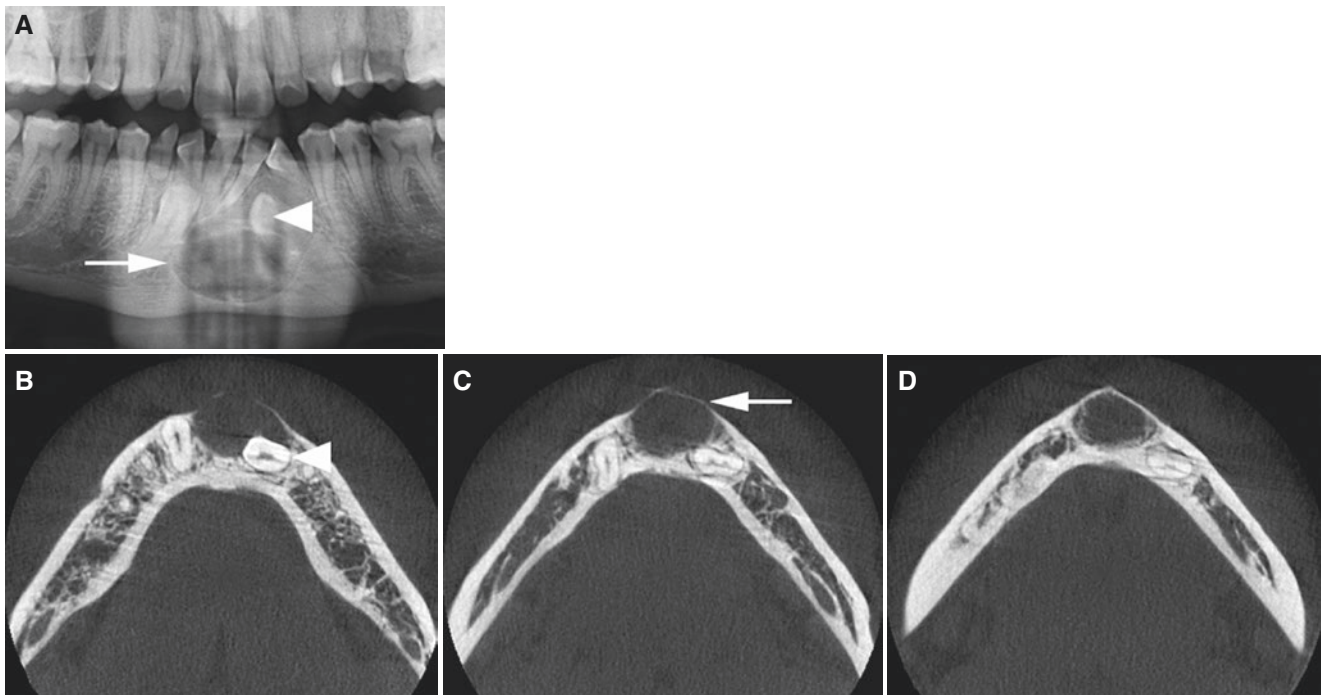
Follicular cyst, mandible; 27-year-old female with swelling in the anterior mandible. (A) Panoramic view shows almost round corticated well-defined radiolucency (*arrow*) surrounding the crown of the impacted tooth (*arrowhead*). (B, C, D) Axial CBCT images show
